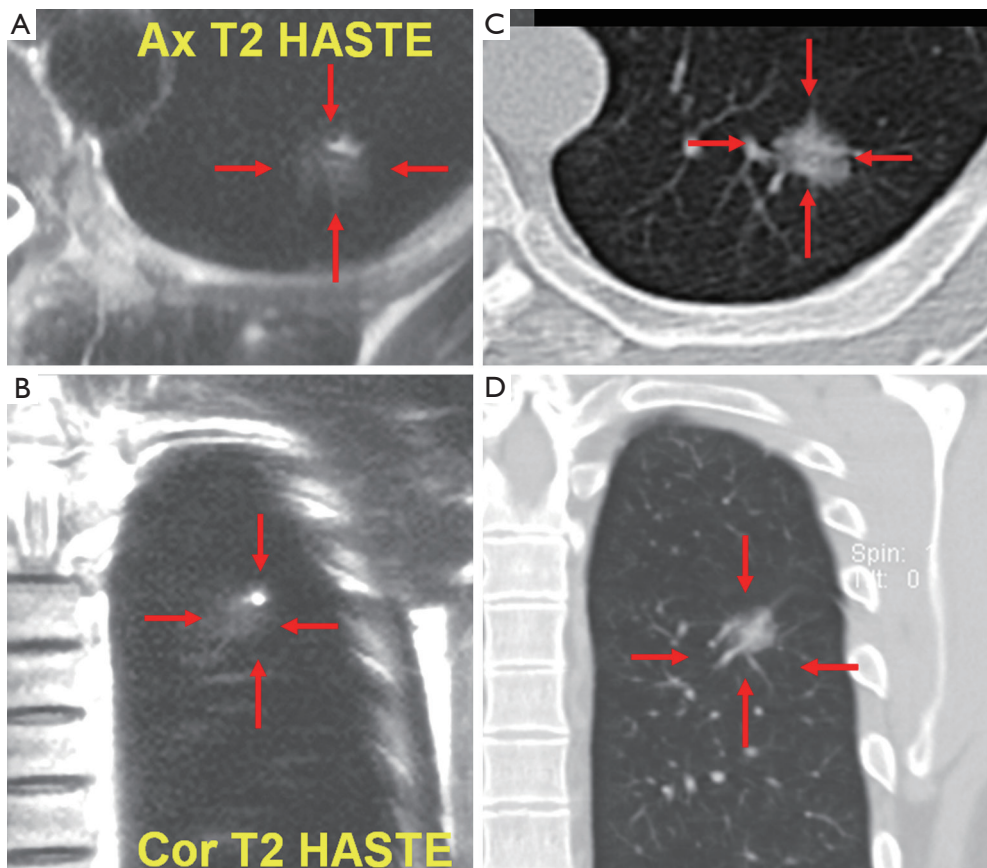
A 42-year-old male. T2 weighted HASTE MR axial (A) and coronal (B) imaging of the chest shows a nodule (arrows). It was also shown by CT (C, axial; D, coronal) and confirmed to be a bronchioalveolar carcinoma by surgery. HASTE, Half-Fourier Acquisition Single-Shot Turbo Spin-Echo.
